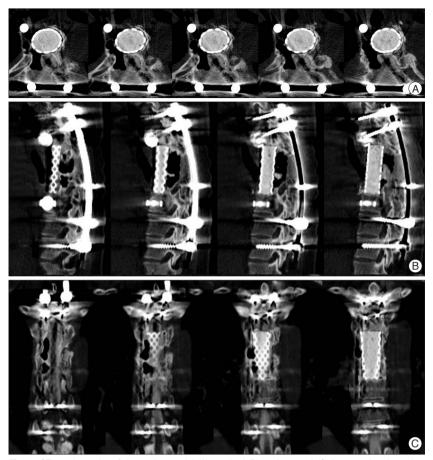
CT myelography of the patient, axial (A), sagittal (B) and coronal (C) images. An air pocket that connected to the right bronchus is seen on the right paraspinal area at the T6 level. Also, an air bubble is present in the subarachnoid space and spinal canal.
